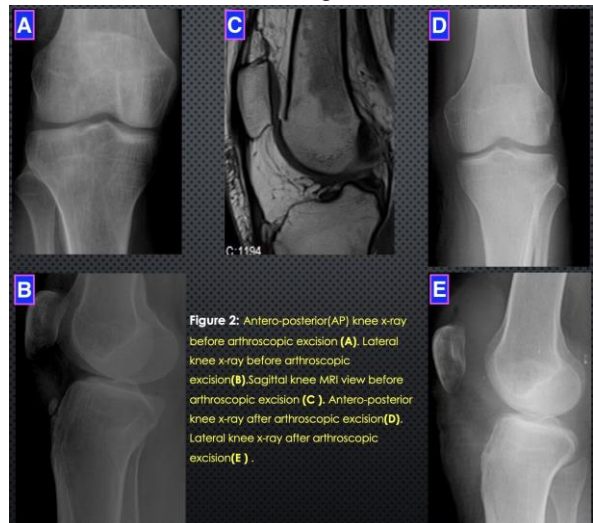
Antero-posterior (AP) knee X-ray before arthroscopic excision (A). Lateral knee X-ray before arthroscopic excision (B). Sagittal knee MRI section before arthroscopic excision (C). Antero-posterior (AP) knee X-ray after arthroscopic excision (D). Lateral knee X-ray after arthroscopic excision (E).
